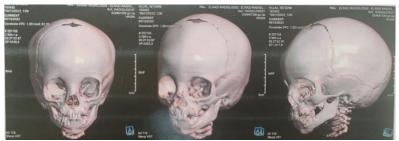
Cerebral CT scan showing trigonocephaly.
